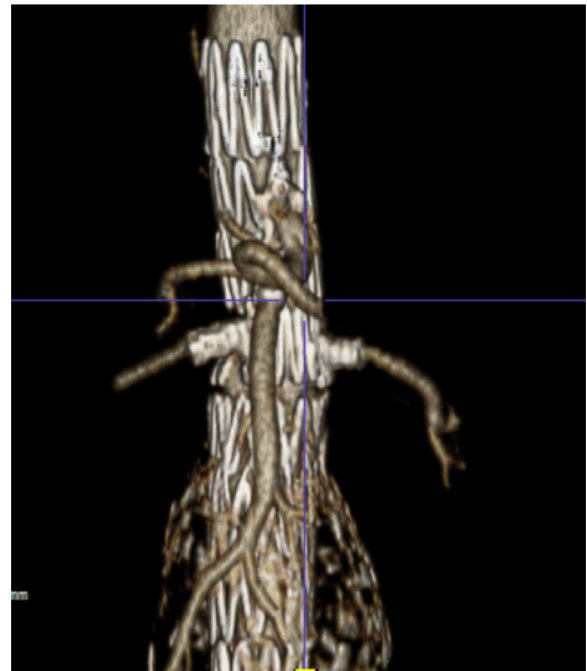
Three-dimensional reconstruction from the 1-month postoperative computed tomography (CT) scan demonstrating the patency of the visceral vessels.
